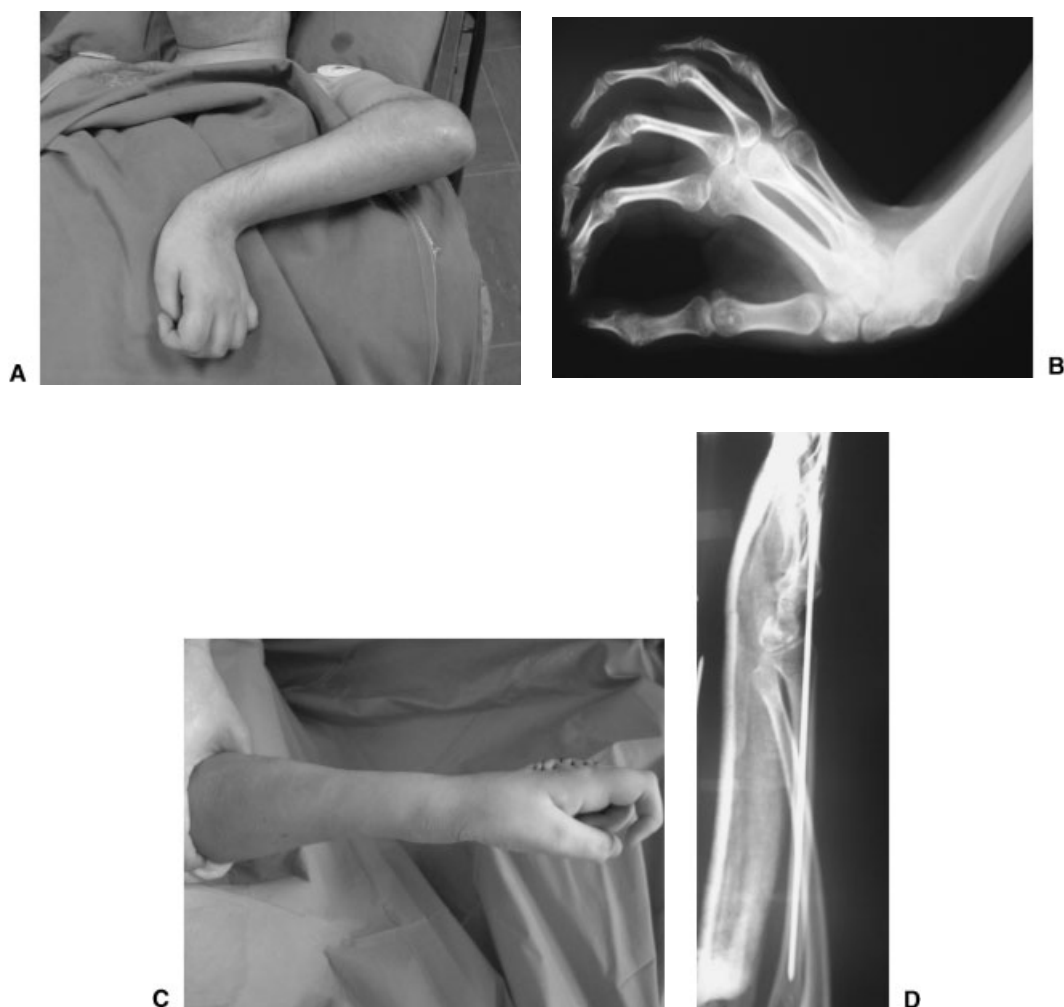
Temporary wrist fusion using a Steinman pin can be successfully used to correct ulnar deviation of the wrist if growth is incomplete. (A) Preoperative picture and (B) radiograph showing ulnar deviation and wrist hyperextension in a 14-year-old boy. (C,D) Postoperative views showing temporary fusion of the wrist using a Steinman pin from the shaft of the radius to the head of the second metacarpal.
